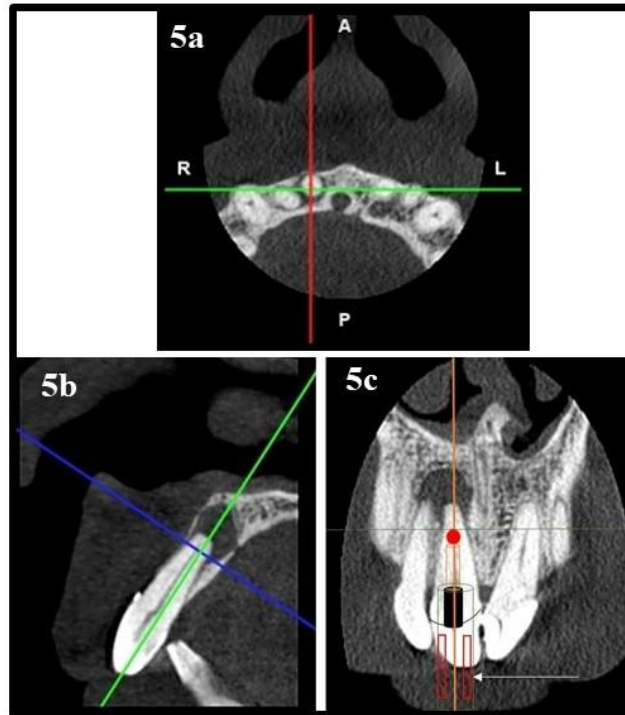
Designing of Endodontic Guide- a) Axial view of the CBCT; b)Tracing the Canal; c) Creating Virtual Drill Path [10]
